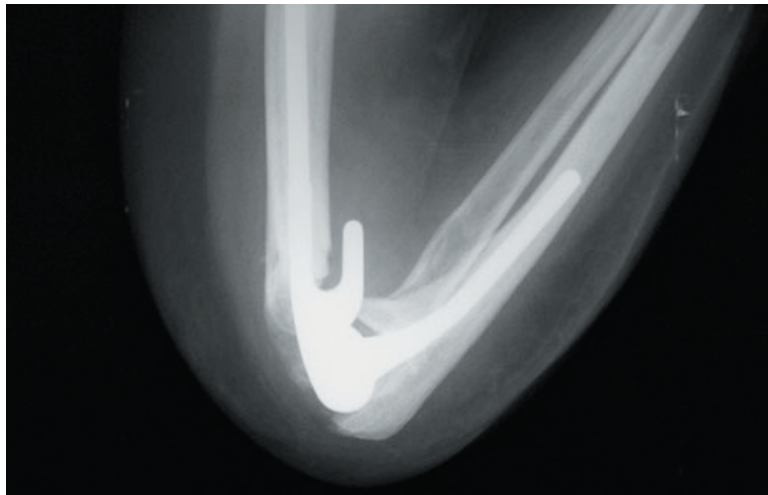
X-ray of elbow joint replacement
